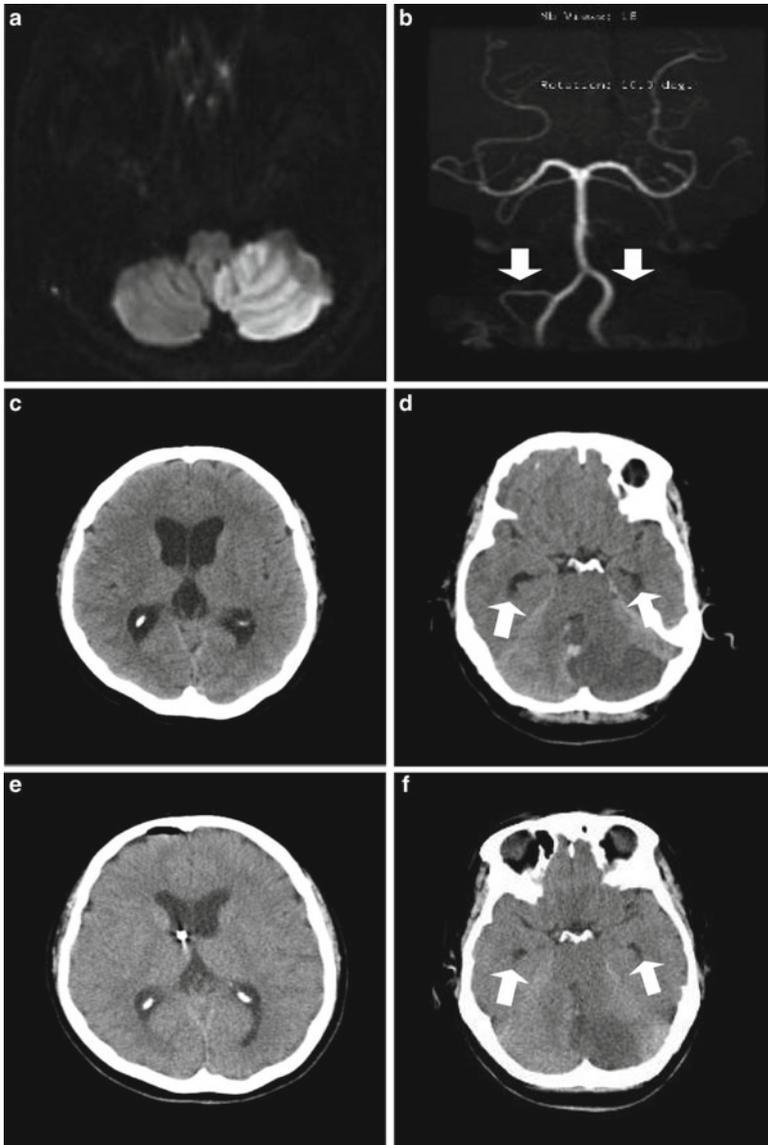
Natural course of space-occupying cerebellar infarction in a woman. Brain MRI (a) and MRA (b) showed left cerebellar infarction in the PICA territory and occlusion of the left PICA (arrow). Her consciousness worsened 2 days after onset, and brain CT (c, d) showed acute hydrocephalus (arrow) and brainstem compression. Ventricular drainage (e, f) resolved the hydrocephalus and her mental status returned to normal
